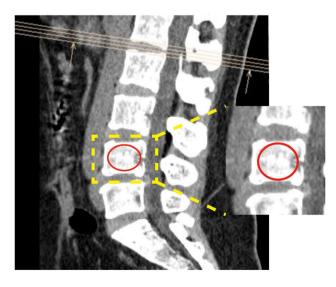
The Hounsfield unit (HU) Value on computed tomography (CT)
